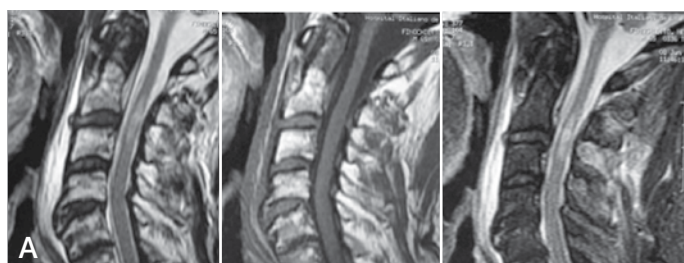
Patient aged 65 years who suffered a fall from a height, (A) Sagittal sections with initial MRI in T2 T1 and STIR, showing intramedullary hematoma C2-C3 with narrowing of the cervical canal, (B) the same sections immediately after surgery. (C) Radiographic control of stenosis of the canal and osteosynthesis material.
